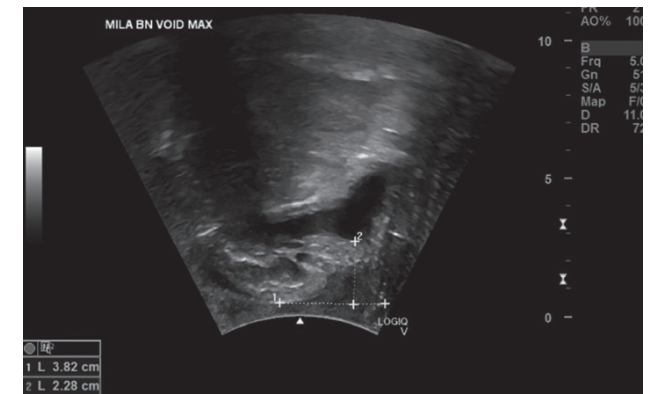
Bladder neck descent (BND) measured by transperineal ultrasound: (a) full bladder [bladder neck position = 3.22 cm (rest) and 2.11 cm (maximum Valsalva); BND = 3.22–2.11 = 1.11 cm]; and (b) empty bladder [bladder neck position = 3.34 cm (rest) and 2.28 cm (maximum Valsalva); BND = 3.34–2.28 = 1.06 cm].
